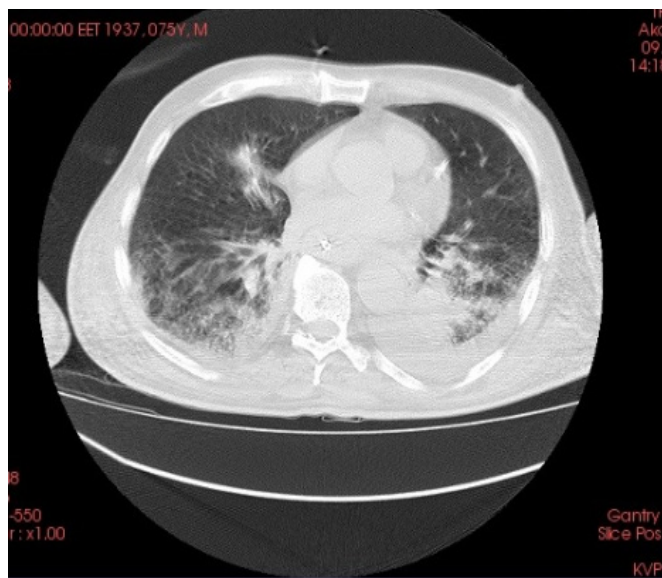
Thoracic CT image of the patient after treatment
